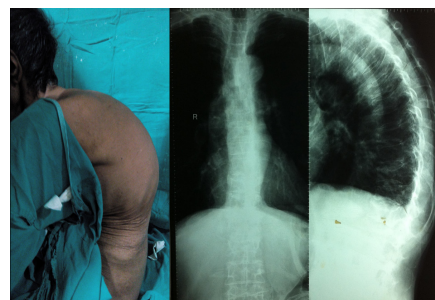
Photograph and radiograph showing senile round kyphosis in the third patient
